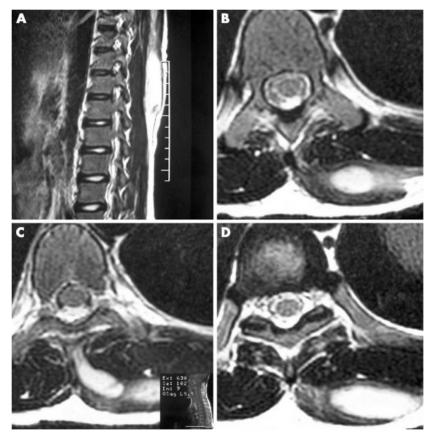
(A) Parasagittal T2 weighted MRI scan of thoracic spine showing intramuscular collection. (B–D) T2 weighted axial images showing left posterior paravertebral muscle collections.
